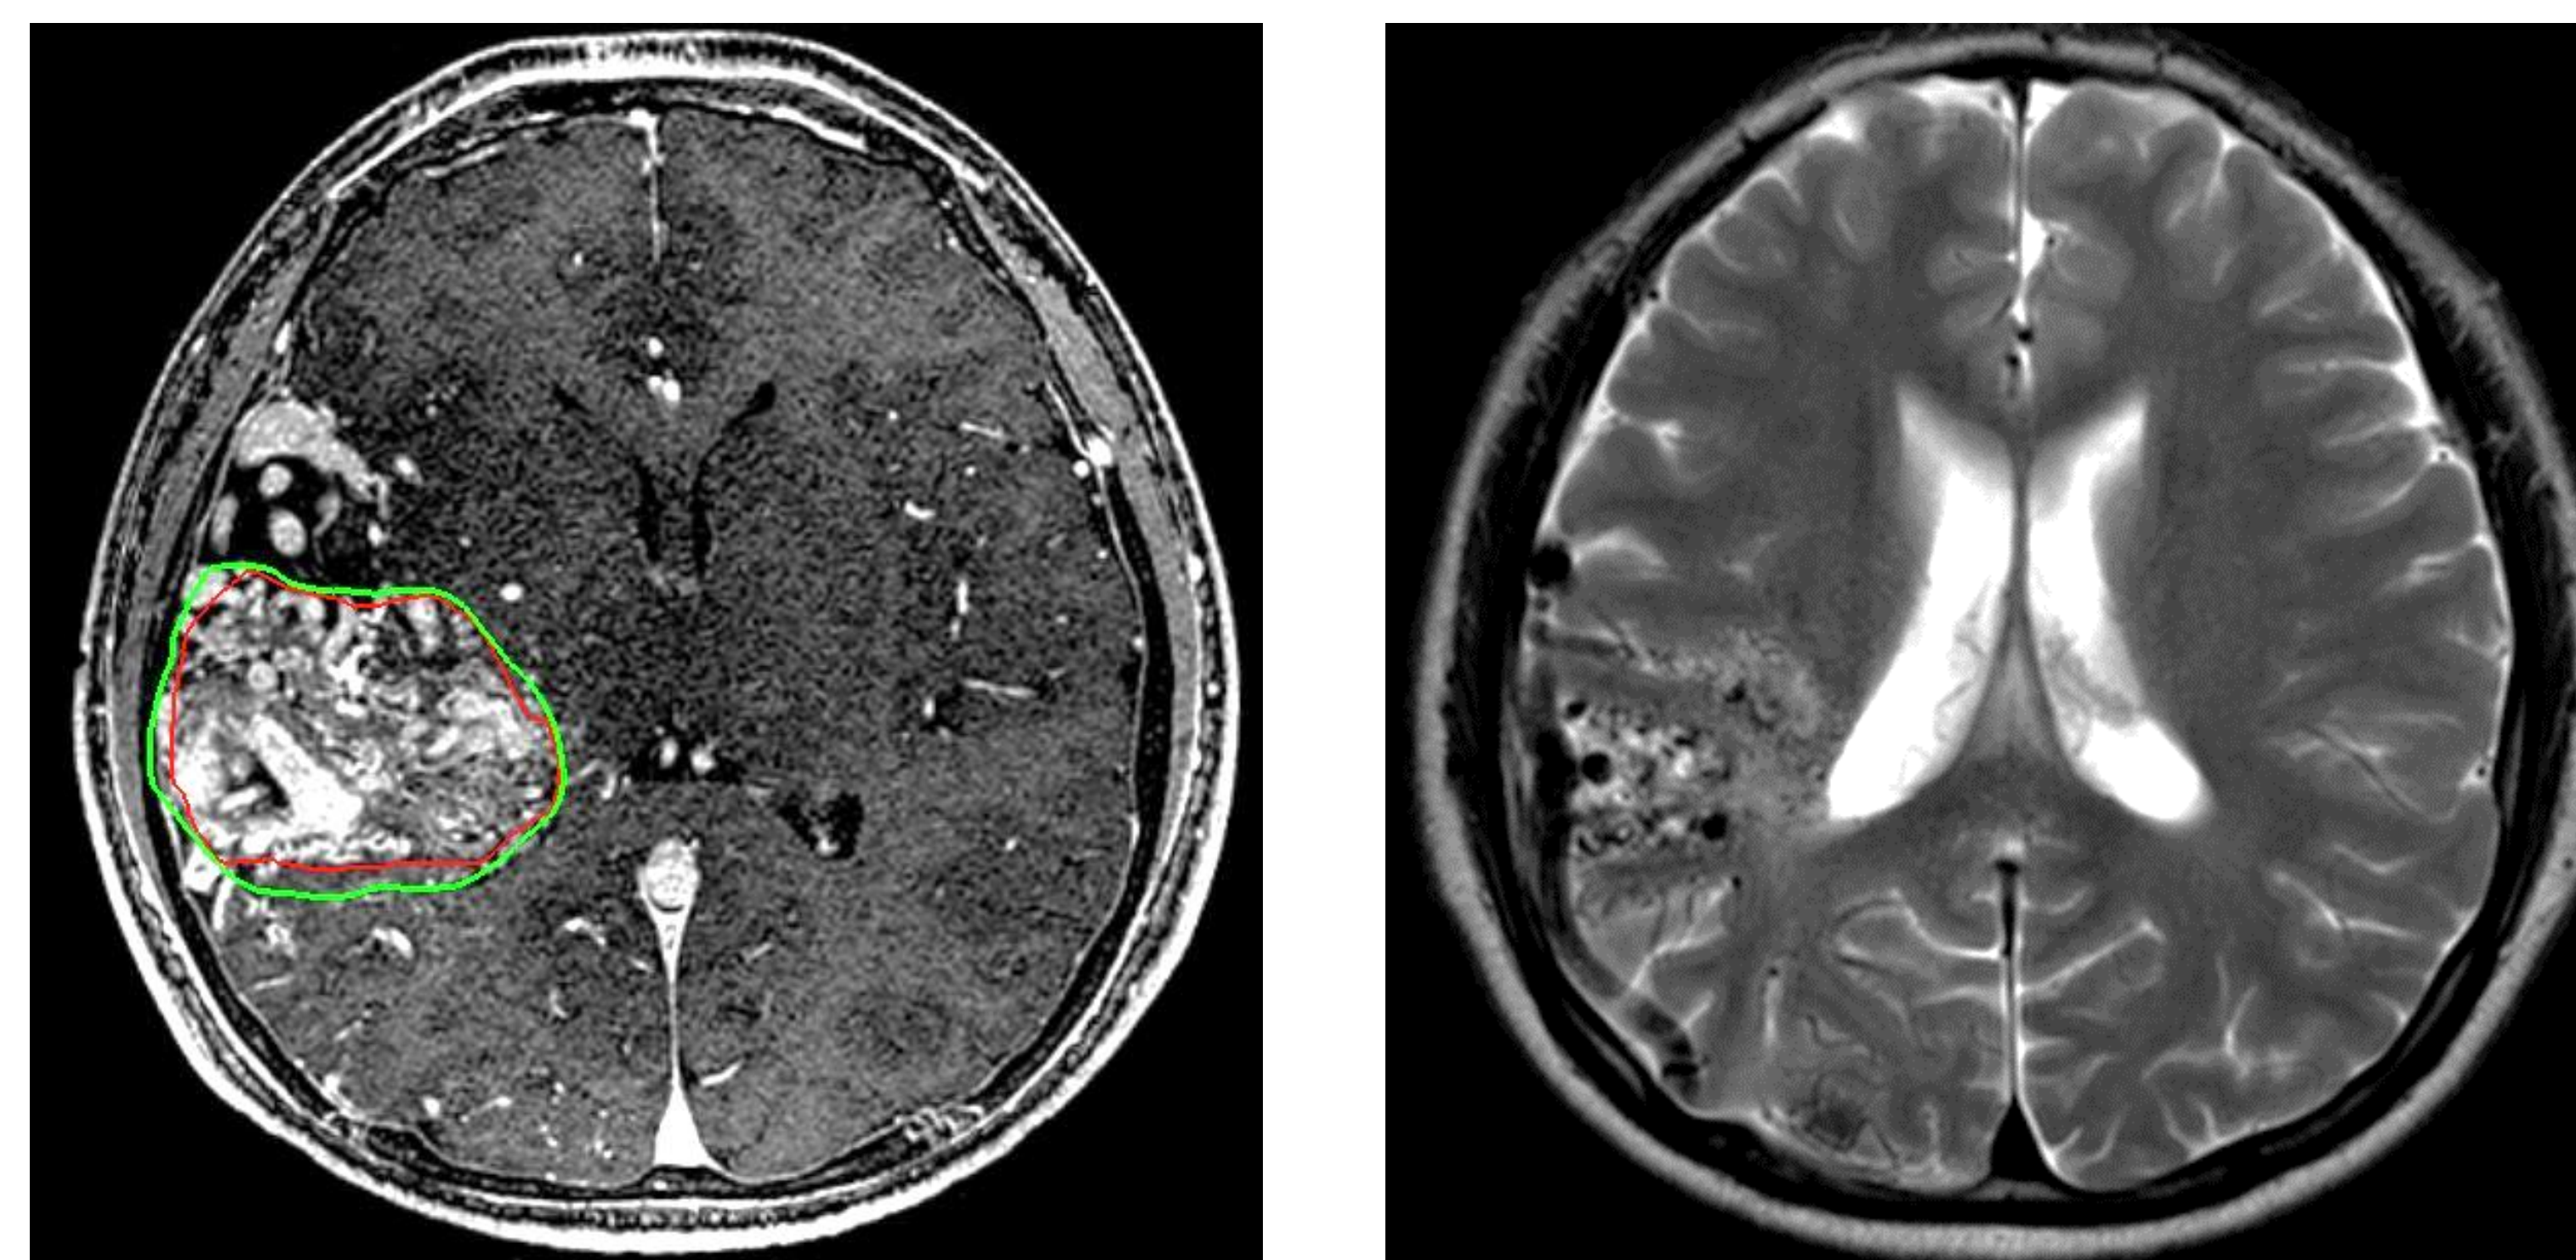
MRI studies from a patient with right parietotemporal, posterior frontal, insular, putamen, and thalamic arteriovenous malformation with predominant MCA arterial supply and superficial venous drainage.
